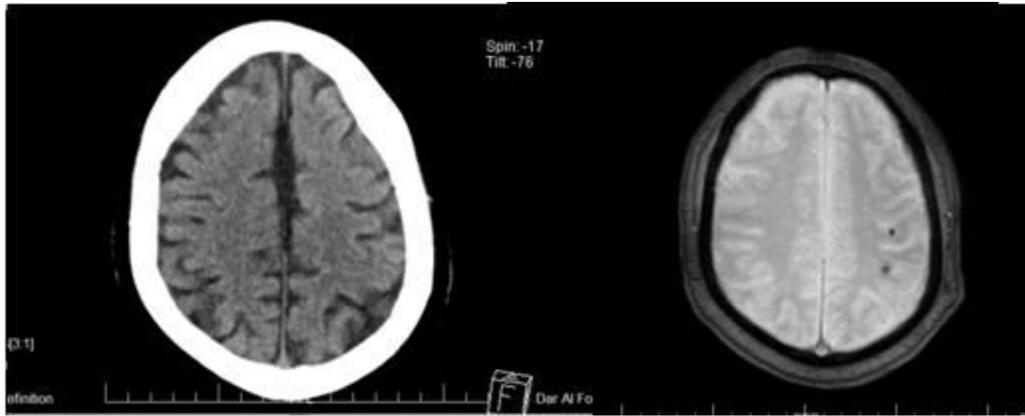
Right image, male patient 64 years old CT brain with no evidence of hemorrhagic changes or calcifications. Left image, T2* shows left high fronto-parietal hypointense foci related to blooming effect of microbleeds.
